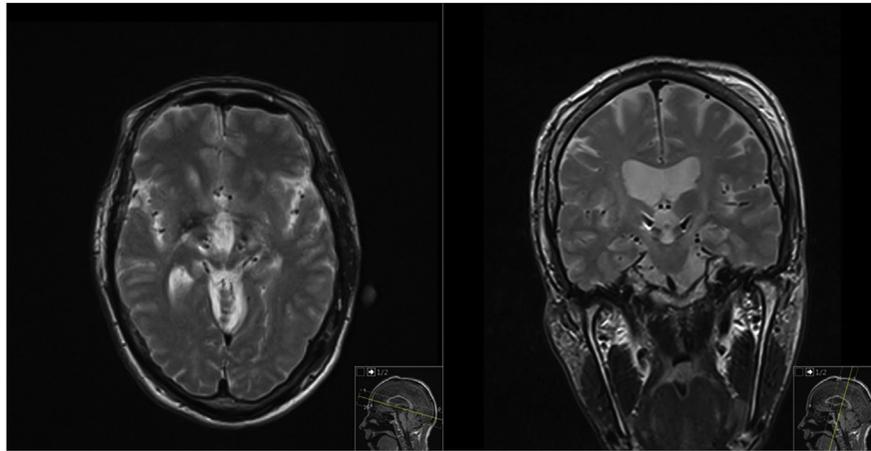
Axial and coronal T2-weighted MRI scans showing the location of the active DBS contact.
